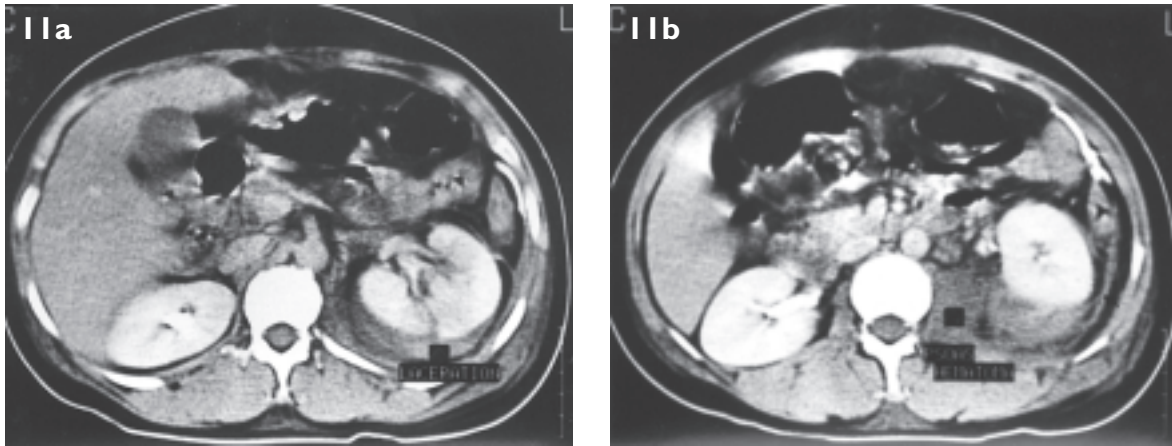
Haemorrhagic involvement of the psoas muscle in a 35-year-old woman injured in a road traffic accident. (a) Enhanced axial CT scan taken at the level of the mid-pole of the left kidney shows a laceration of the posterior parenchyma of the left kidney (labelled) and a rim of perinephric haematoma. (b) Enhanced axial CT scan taken at the level of the lower pole of the left kidney shows extension of the left perinephric haematoma to the left psoas muscle (labelled).
